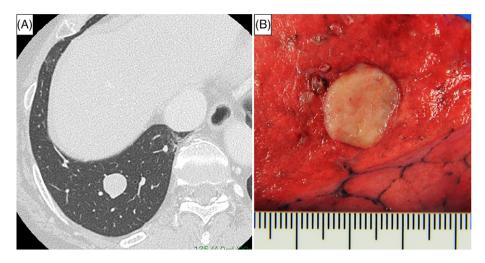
Computed tomography and macroscopic images of PPM. CT revealed a 2-cm-sized solid nodule in the right lung (A). The cut surface of the tumor showed a well-demarcated, yellowish-white, firm and solid nodule (B) [Color figure can be viewed at wileyonlinelibrary.com]
